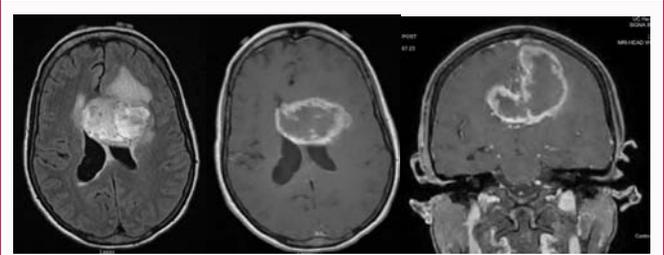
MRI dated 9/3/2019 demonstrating 6.5 × 4.3 × 6.5 cm (transverse × anteroposterior × craniocaudal) lesion. Sequences are (from left-to-right) axial T2 FLAIR, axial T1 post-contrast, coronal T1 post-contrast.
